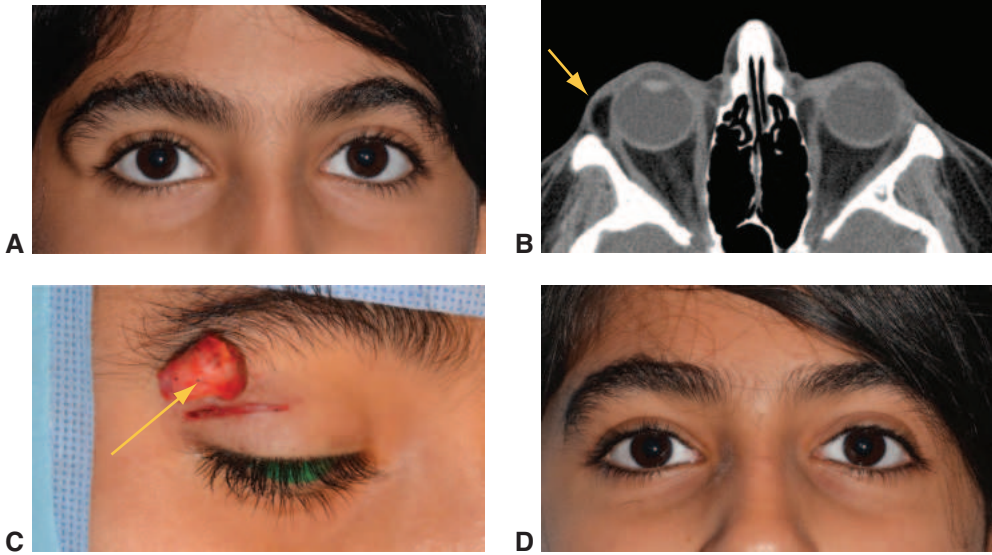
Orbital dermoid cyst. A, Child with fullness of the right superolateral orbit. B, CT scan of the hypointense lesion (*arrow*) in the axial plane is characteristic of a dermoid cyst (epithelial choristoma); note its location at the frontozygomatic suture line. C, Dermoid cyst removed through an upper eyelid crease incision shows dermal appendages (*arrow*). D, Post-operative photograph shows resolution of the eyelid fullness. (Courtesy of Bobby S. Korn, MD, PhD.)
